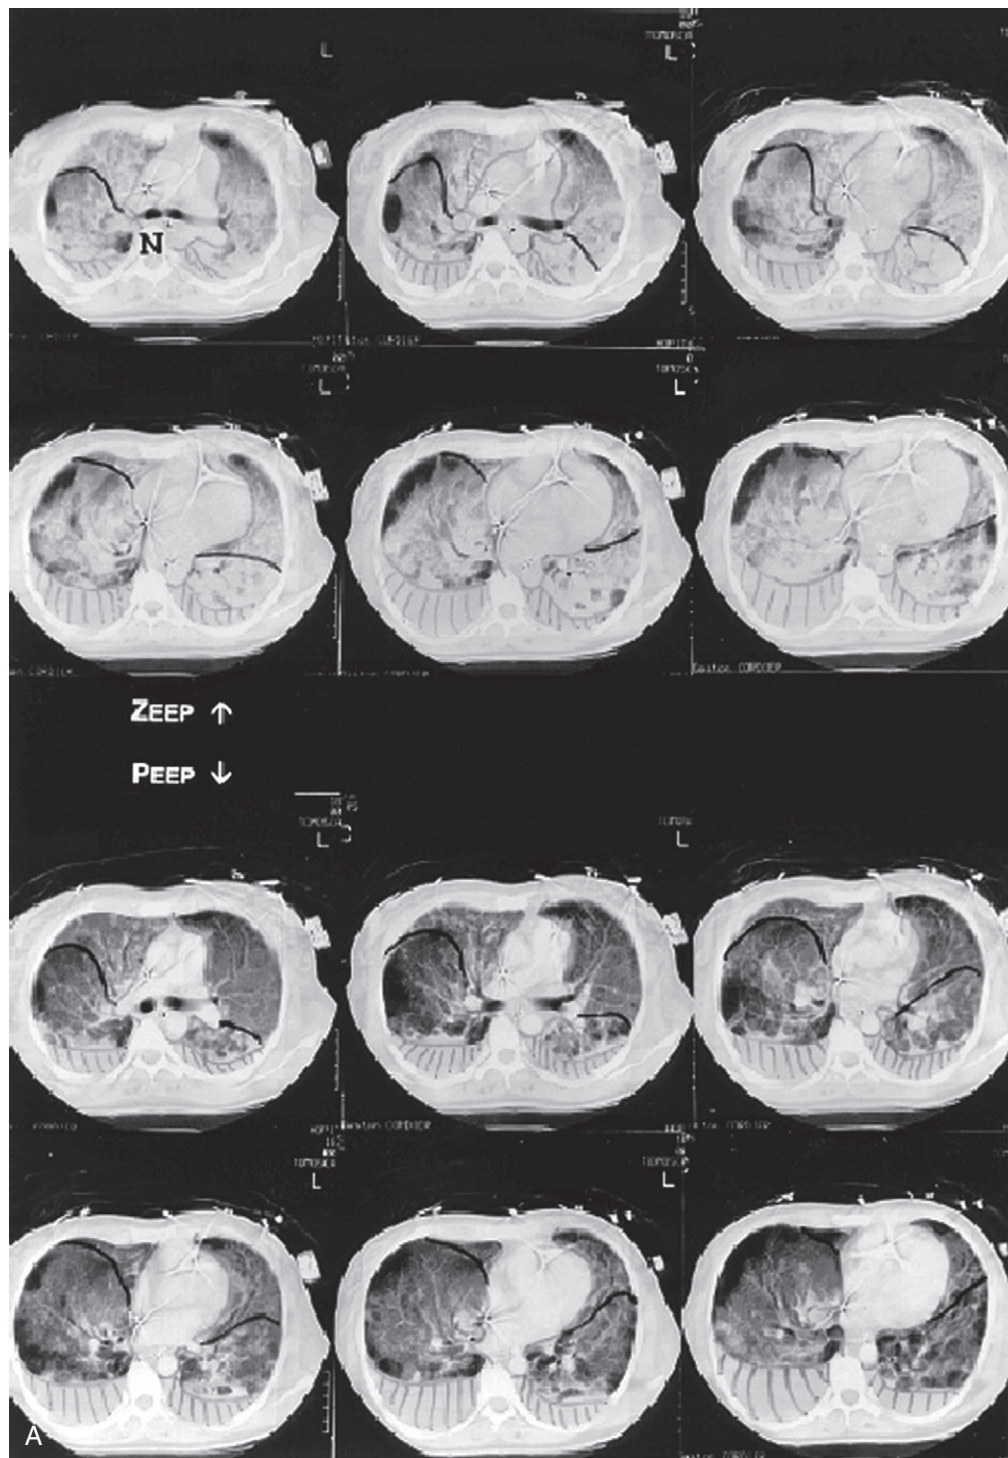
Divergent effects of positive end-expiratory pressure (PEEP; lower panels) as compared to zero end-expiratory pressure (ZEEP; upper panels) on regional lung recruitment assessed by computed tomography. A, In the acute diffuse form of acute respiratory distress syndrome (left panels), and B, the 'lobar' form (right panels), PEEP induced a marked lung recruitment of the edematous zones, but a marked overdistension of aerated zones in pneumonia (the black line shows the scissura and the hatched area the pleural effusion). (From Puybasset L, et al: *Am J Respir Crit Care Med* 159:1644-1655, 1998.)
